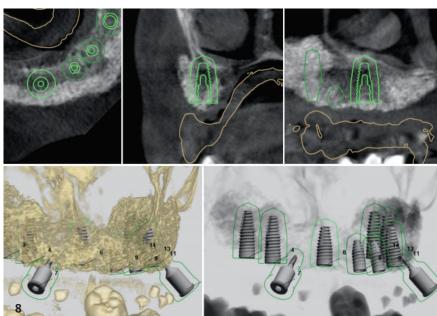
Six-month CBCT confirms successful bone integration for implant placement. – Fig. 8: Precise implant positioning with 3D digital planning.
